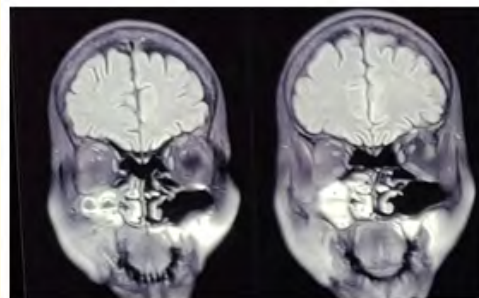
T1 weighted MRI PNS-Orbit depicting Mucor involvement of Rt. PNS and Orbit.
